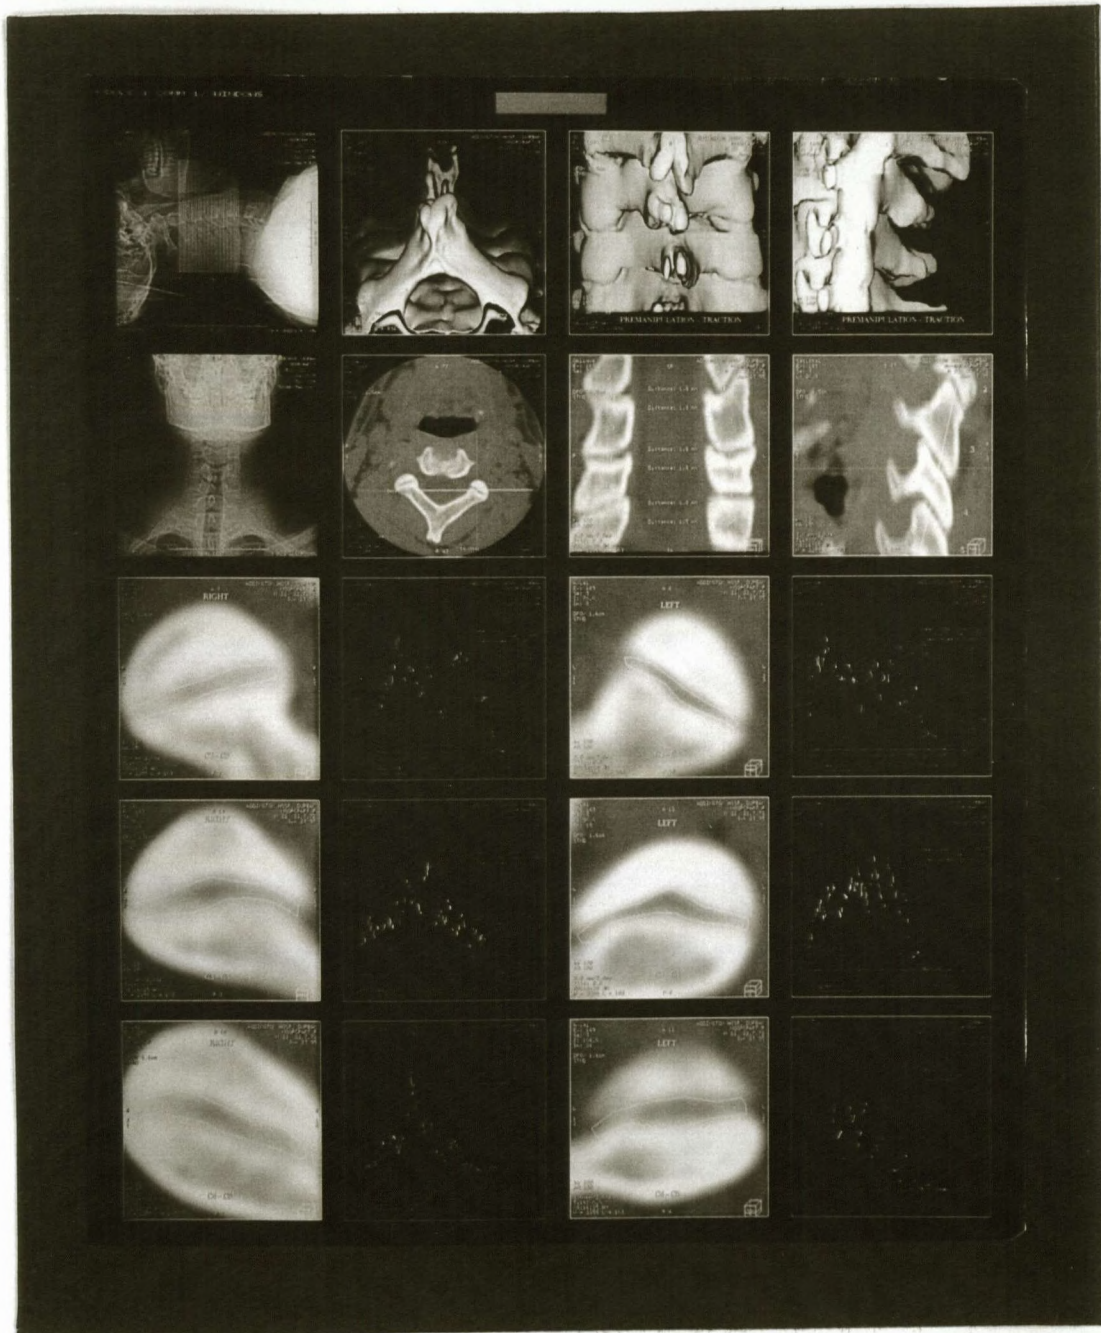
Experiment 3 : Post-manipulation CT scan
